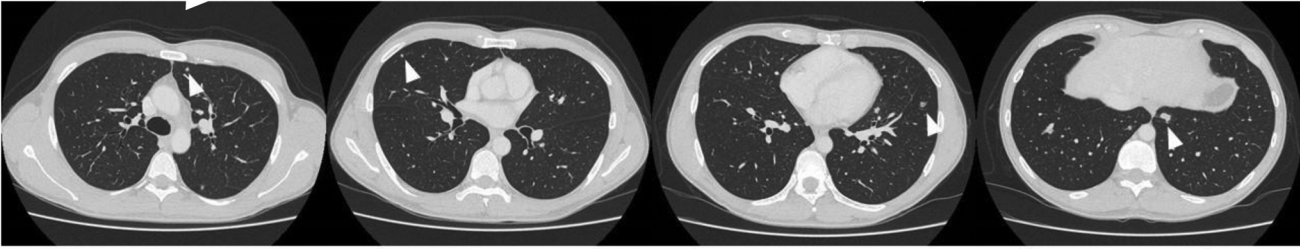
Multiple bilateral recurrent lung metastasis revealed using computed tomography (white arrowhead).
